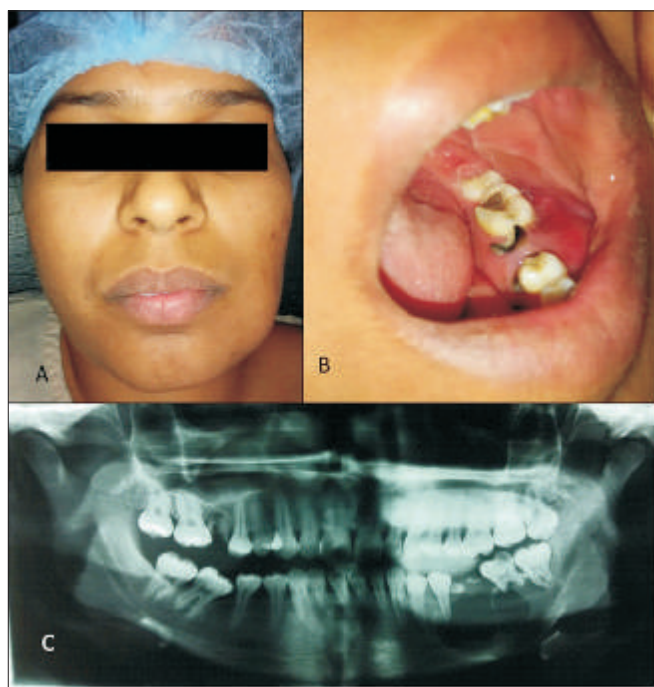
(A)- Preoperative facial photograph showing swelling over left mandibular body region. (B)- Preoperative intraoral photograph showing expansion of mandibular bone both buccally and lingually. Displacement of teeth can also be noticed. (C) - Preoperative orthopantomogram showing multilocular cystic radiolucency at left mandibular body region with cortical expansion and displacement of associated teeth.
